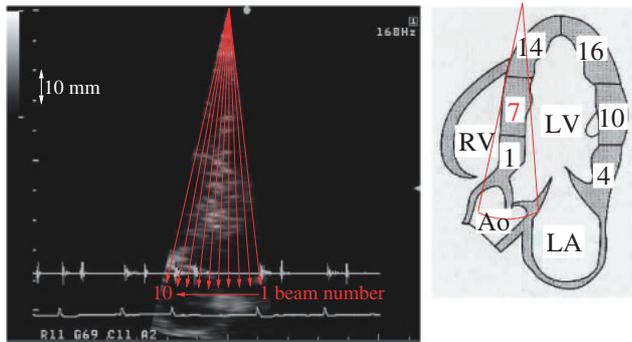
Left: Cross-sectional image of left ventricle in apical approach obtained by conventional echocardiography for 79-year-old male with OMI. The arrows show the directions of the 10 ultrasonic beams used for the acquisition of RF signals in the IVS. Right: Segmentation in the apical long-axis view.¹⁸⁾
